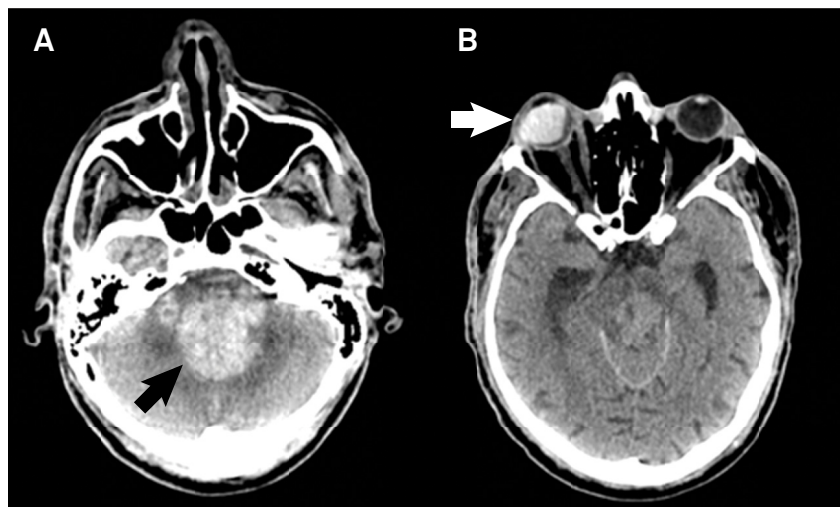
Computed tomography (CT) showed a hemorrhage in the brainstem and in the vermis of the cerebellum (black arrow in A) and an intraocular hemorrhage in the right eye (white arrow in B), which appeared as spontaneously hyperdense areas on the CT.
